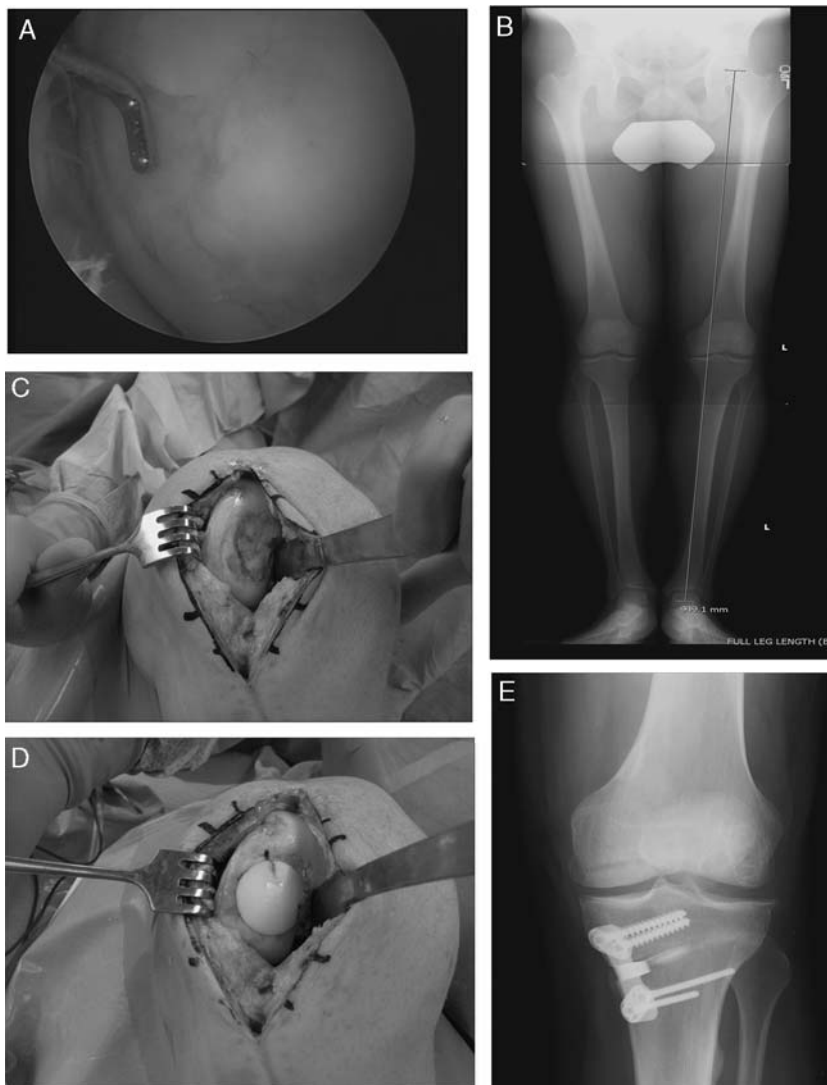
A 38-year-old active duty officer presented with a medial knee pain after undergoing a right autograft osteochondral transfer to his medial femoral condyle 10 years ago. His staging arthroscopy image (A) showed diffuse loss of articular cartilage with some maintenance at the site of osteochondral plugs. He underwent an open-wedge-high-tibial osteotomy for his varus deformity (B) and a subsequent allograft osteochondral transplantation for his diffuse chondral damage (C) using a single 30 mm plug (D). Final postoperative anteroposterior radiograph is shown (E).
